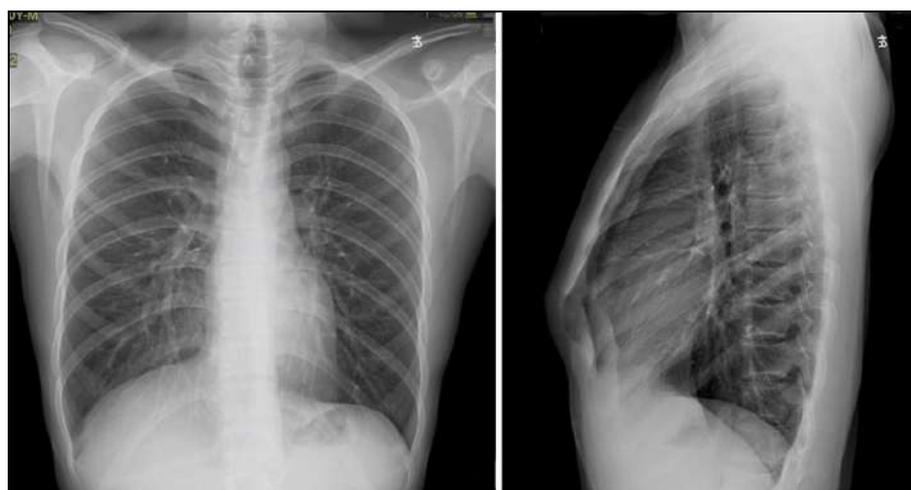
X-ray of the chest before the operation.
